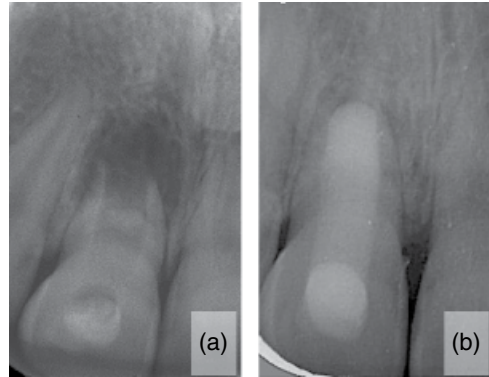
Apexification. The infected canal (a) was cleansed with light instrumentation and copious irrigation, followed by a dressing of calcium hydroxide. Four mm of MTA was packed in the apical part and the tooth root-filled with a resin restoration coronally. The 15-year follow-up radiograph shows dental hard tissue formation with generation of a complete periodontal ligament (b). (Reproduced with permission from [172].)
